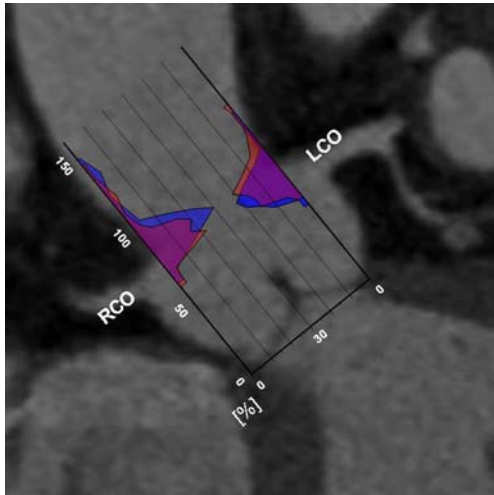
Distribution of coronary ostial locations as a percentage of sinus heights overlaid on multiplanar CT reconstruction visualizing the anatomy of the aortic root in a symptomatic patient with severe tricuspid AS. No differences were found in regard to the ostial locations when patients with severe tricuspid AS (red area) were compared with patients without valvular disease (blue area). Note the lower location of the LCO when compared with the ostium of the right coronary artery (RCO)
